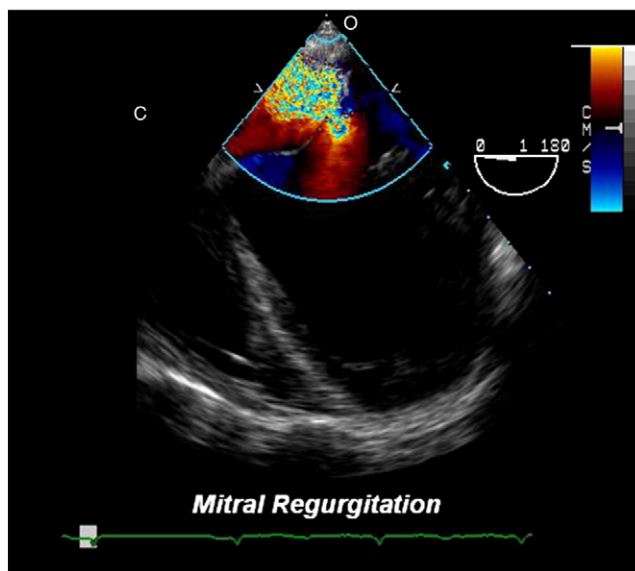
Transesophageal echocardiographic view of severe central mitral regurgitation.
